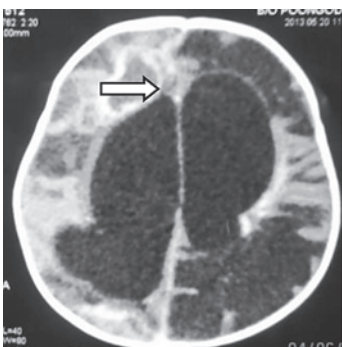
Contrast CT brain - Right frontal abscess with hydrocephalus
